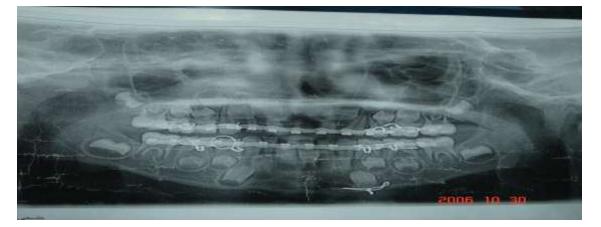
Orthopantomogram of child patient treated by Closed reduction & indirect skeletal fixation 2-3 week
